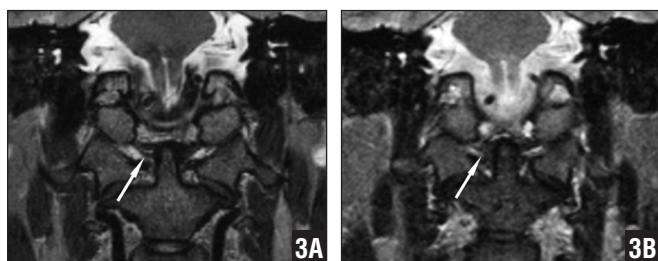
Three-T magnetic resonance image showing well-defined alar (arrow) and transverse ligaments (A). One point five-T magnetic resonance images showing that the inhomogeneity of the right alar ligament (arrow) visible on the 3-T image is not clearly visualized.
